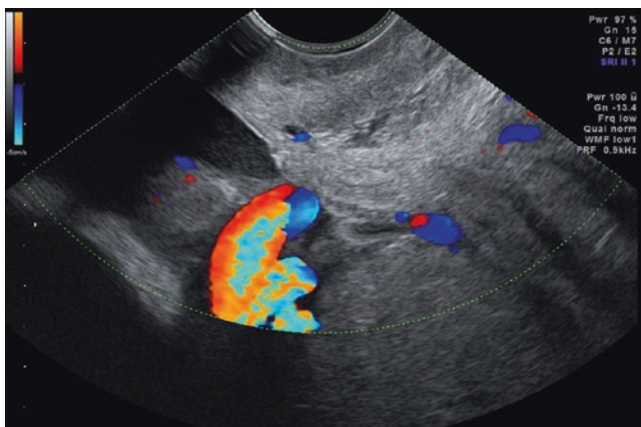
Vasa previa at color Doppler
